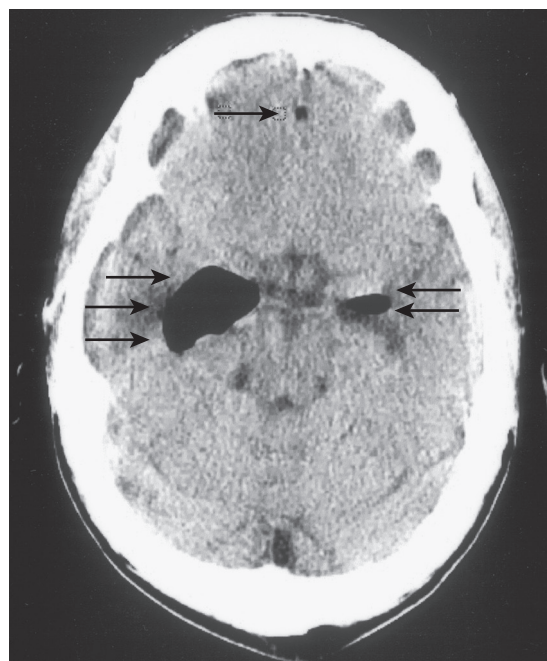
■ A CT scan of the brain demonstrating the pathognomonic finding of air within the ventricular system of the brain (arrows) secondary to a bronchopleural-subarachnoid fistula from a combined chest wall, lung, and vertebral body resection.
